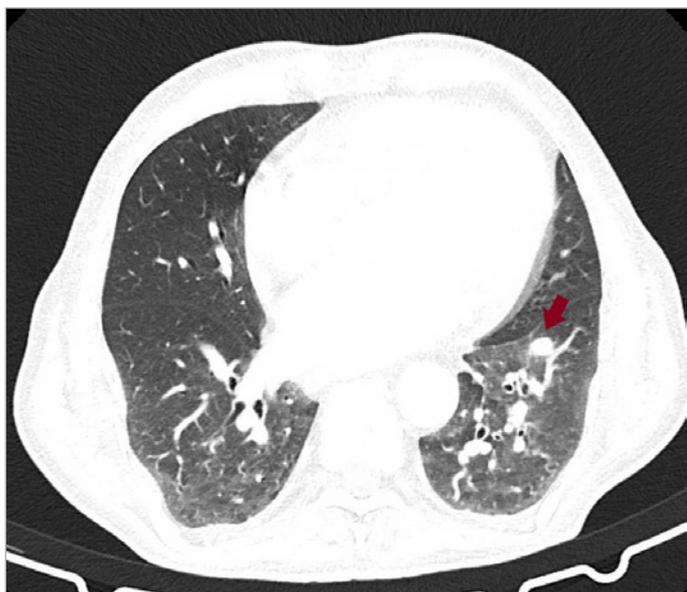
CT. Nodule in left lower lobe.
